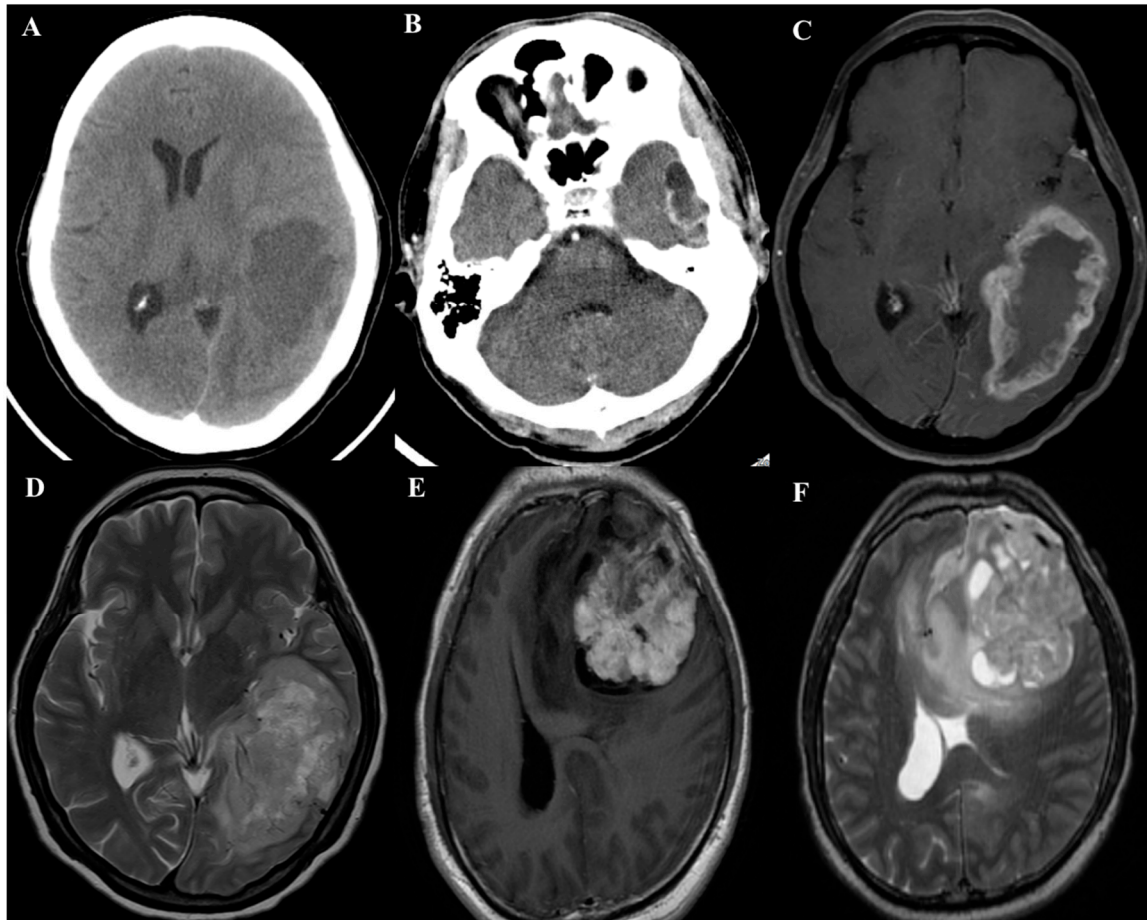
GBM. (A) The axial brain CT without contrast shows an irregular mass with central necrosis over the left temporo-parieto-occipital lobes with prominent edematous effect with midline-shifting. (B) The axial brain CT with contrast shows multiple lobulated cystic structures with enhanced wall and septi over the left temporal lobe. (C) The axial brain magnetic brain imaging, T1-weighted repetition time (TR), 450 ms; echo time (TE), 10 s, Achieva 1.5 T, Philips] image with gadolinium contrast demonstrated an irregular rim enhanced mass with large central necrosis at the left temporo-parieto-occipital lobes. The prominent edematous effect completely compressed the occipital horn of the left lateral ventricle. (D) The axial brain MRI, T2-weighted (TR, 4980 ms; TE, 100 s) image with gadolinium contrast demonstrated an irregular ovoid mass with necrosis at the left temporo-parieto-occipital lobes. The edematous effect and mass effect were prominent. (E) The axial brain MRI, T1-weighted image with gadolinium contrast demonstrated an irregularly enhanced mass with central necrosis involving the left frontal lobe. The prominent edematous change resulted in brain herniation across the midline. (F) The axial T2-weighted image showed a remarkable perifocal edema in the left frontal lobe, extending to the insula, and corpus callosum genu with subfalcine herniation.
